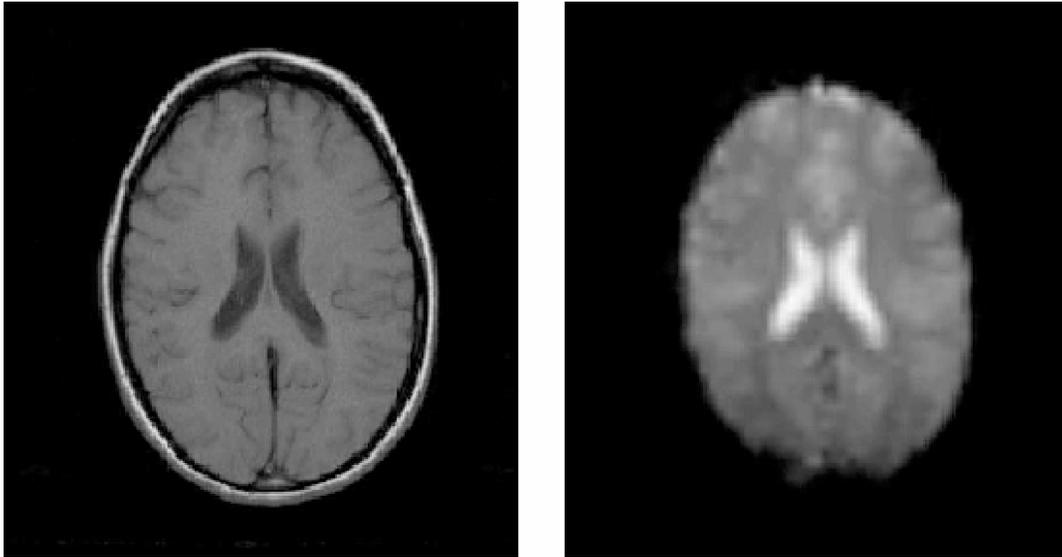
Left is high-resolution T1-weighted image with cervical spinal fluid appearing black. Right is a low-resolution T2-weighted image with cerebral spinal fluid appearing white.
